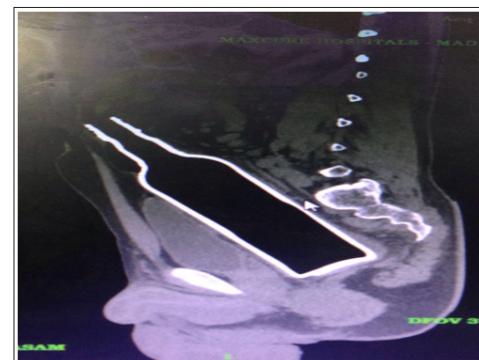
CT Abdomen Showing-Foreign Body
